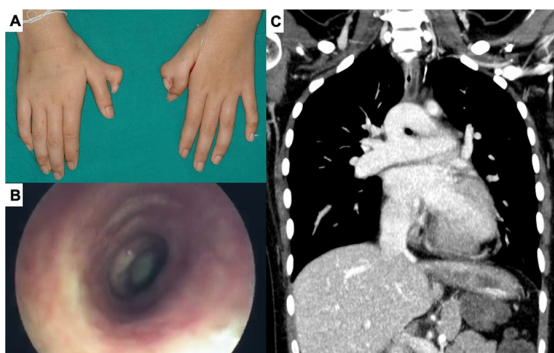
A) Radial polydactyly on both upper extremities, B) Circumferential tracheal stenosis from bronchoscope view, C) Pulmonary arterial sling (PAS) from CT pulmonary angiogram.
